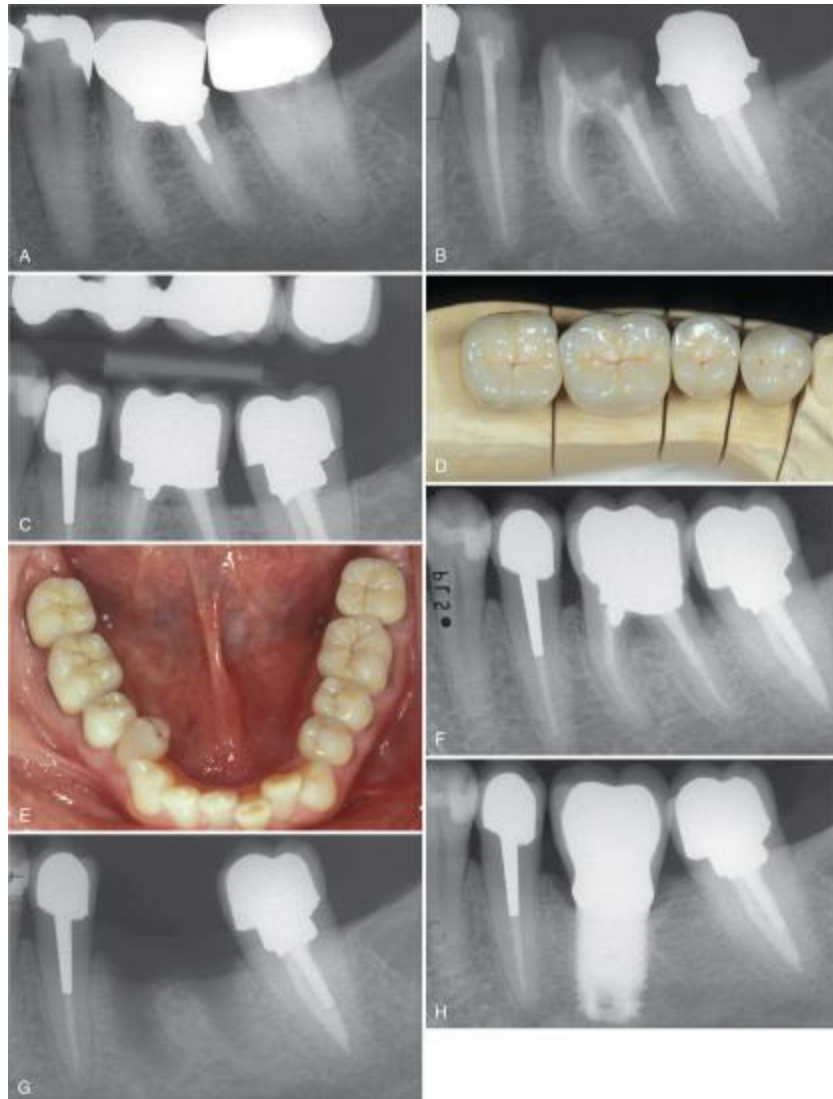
The negative impact of poor initial biomechanical status on restoration success. A and B, Preoperative radiographic views following the removal of the old metallic foundation. C, A new amalgam core, using post and self-anchorage into mesial root structure, was performed. D, Prosthetic restorations on working model. E, Full arch view after 3 years. F, The tooth is symptomatic due to furcation involvement and periapical lesion. G, This untreatable tooth was finally
